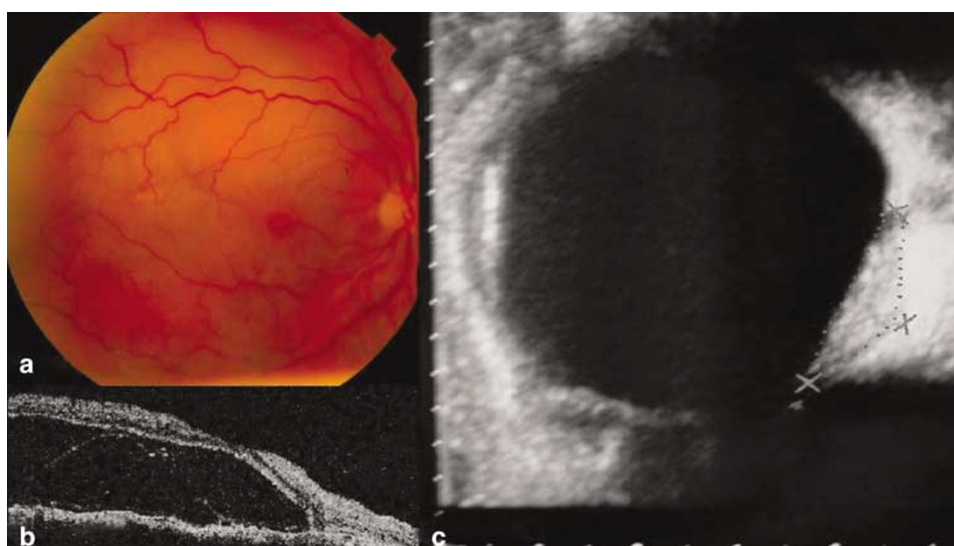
(a) Funduscopy at baseline. Yellowish mass in the posterior pole of the right eye. (b) OCT scan at baseline. Serous retinal detachment. Intraretinal and subretinal fluid collections. (c) B-mode ultrasonography at baseline. Choroidal mass with an extension of 15.9 × 11.8 mm and a thickness of 2.9 mm.
